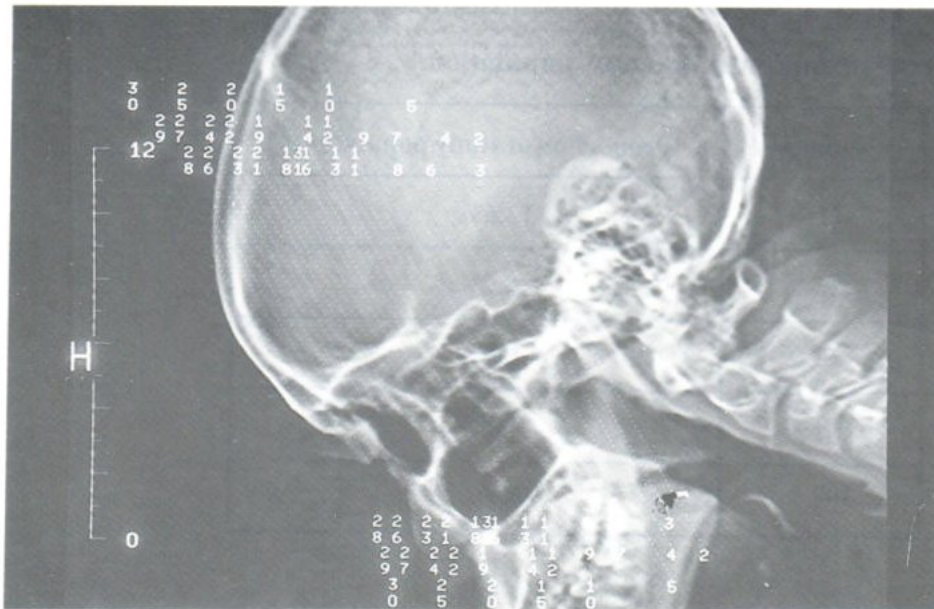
Lateral scout image of patient undergoing screening sinus CT .
